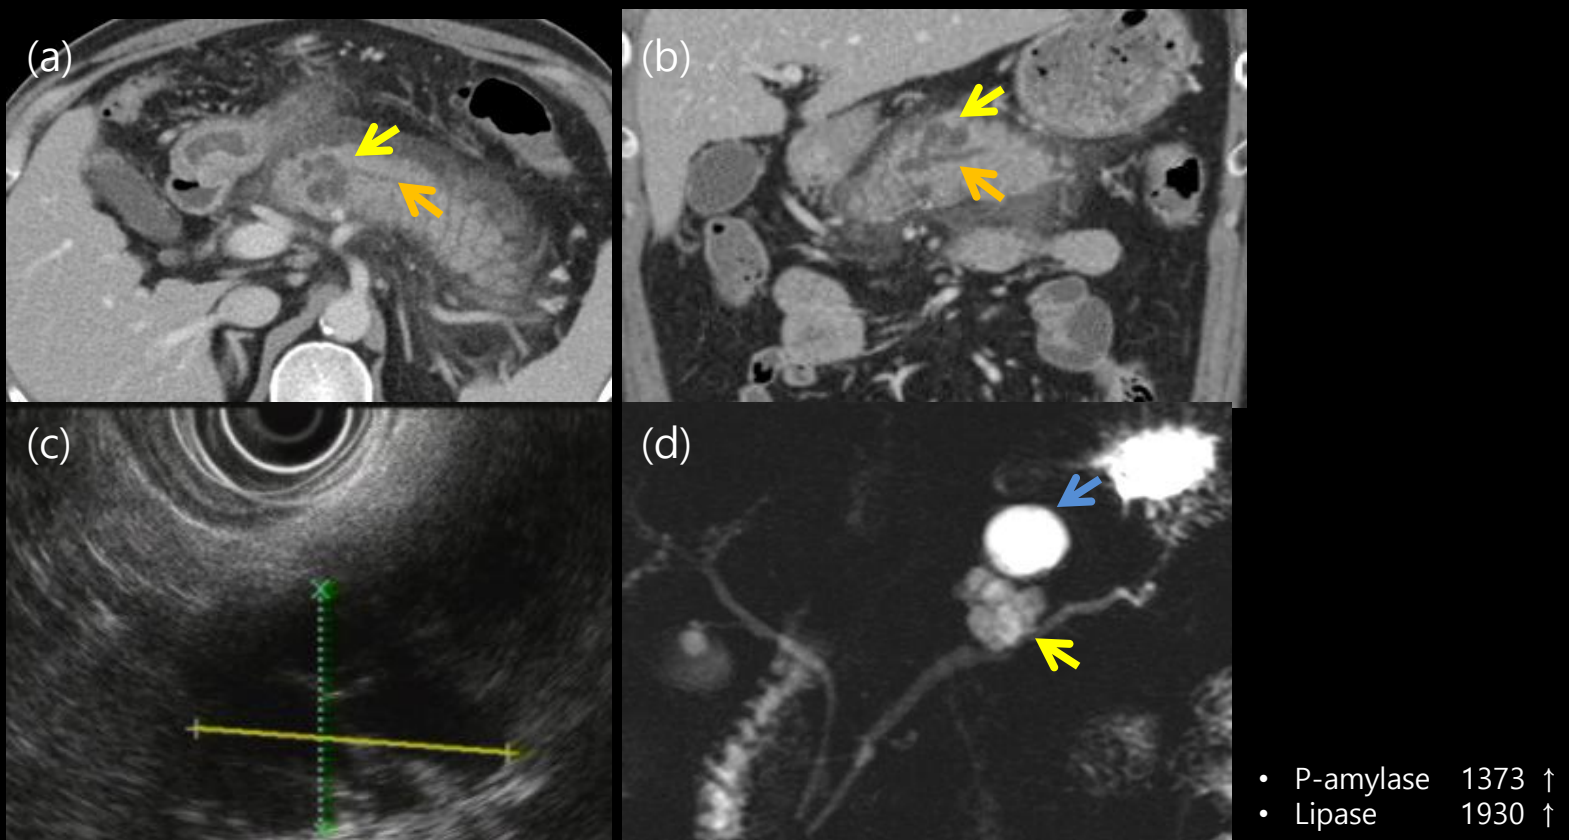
52 years old man presented with acute pancreatitis by malignant IPMN. (a), (b) Axial contrast material-enhanced abdomen CT images & coronal oblique reconstructed image show diffuse pancreatic swelling with peripancreatic infiltration, fluid collection and multi-loculated cystic lesion (yellow arrow) in pancreatic body with dilated pancreatic duct of lesion. (orange arrow) (c) Endoscopic ultrasonography depicts well defined multilocular cystic mass (about 2.6 x 2.0 cm in size) (d) Multi-lobulating septated cystic lesion with communicating with pancreatic duct (yellow arrowed) in MRCP. Unilocular cystic lesion (blue arrow) with brighter signal intensity is suggested pseudocyst.
